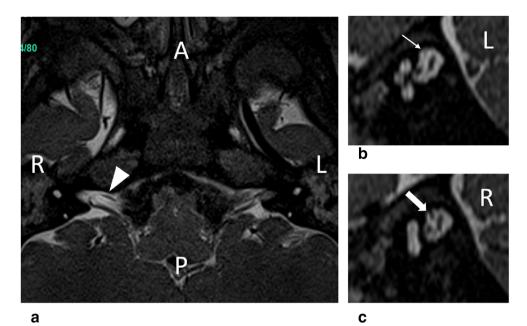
MRI images of patient 2 performed in 2012. a Axial 0.4-mm 3Dconstructive interference in steady state (3D-CISS) sequence shows an aplasia of the right facial nerve (white arrowhead). b Parasagittal 0.5-mm reconstructions through the right internal auditory canal (IAC) show an
